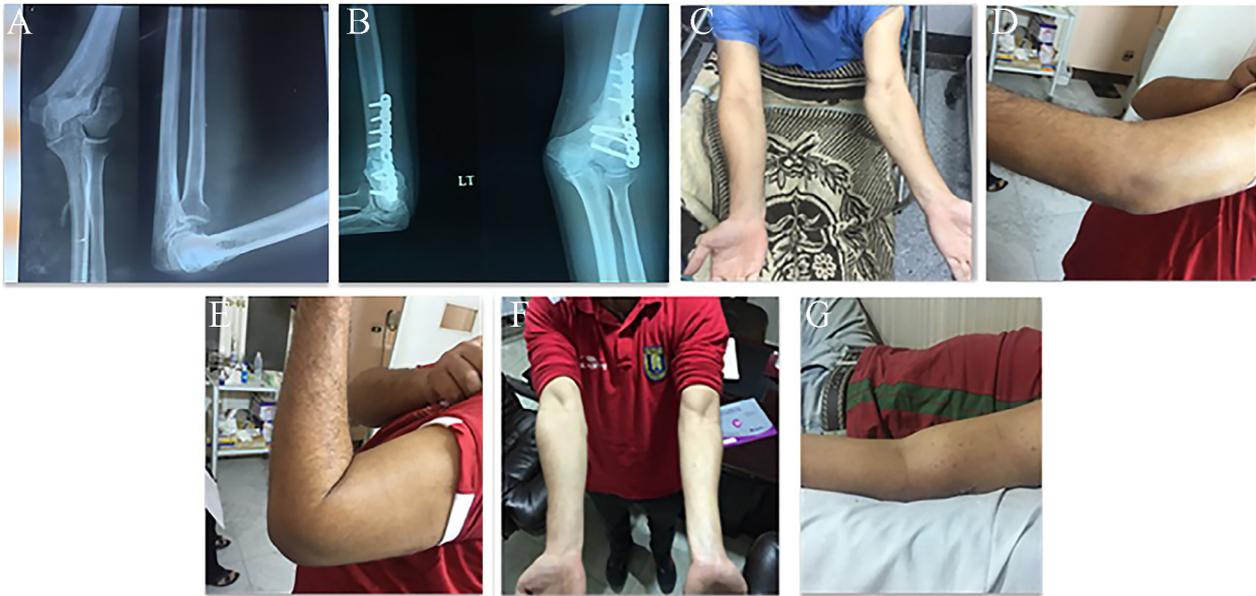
(A) Preoperative X-ray; (B) Post-operative X-ray; (C) pre-operative deformity; (D) pre-operative extension range; (E) pre-operative flexion ROM; and (F,G) post-operative ROM.
